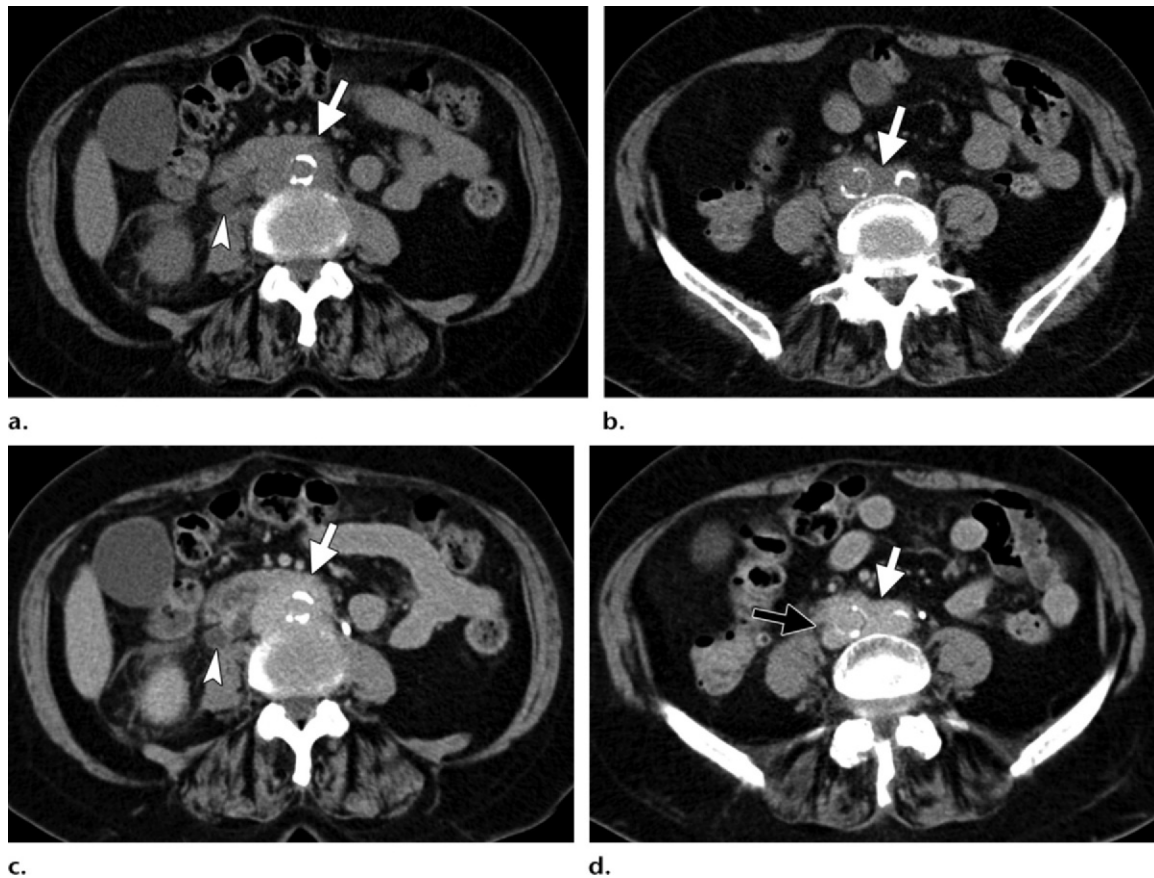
CT of RPF. (a, b) Axial nonenhanced CT images show an irregular retroperitoneal mass (arrow) that is isoattenuating to muscle. The mass is located anterior and lateral to the lower abdominal aorta and iliac arteries; it spares the posterior aspect of the aorta and does not cause anterior aortic displacement. Arrowhead in a = right proximal hydroureter. (c, d) Contrast-enhanced CT images obtained 180 seconds after contrast material administration show avid enhancement of the mass (white arrow), a finding suggestive of early-stage RPF. The right proximal hydroureter (arrowhead in c) is secondary to distal encasement of the ureter by the mass (black arrow in d). Note the delayed renal excretion of contrast material.
